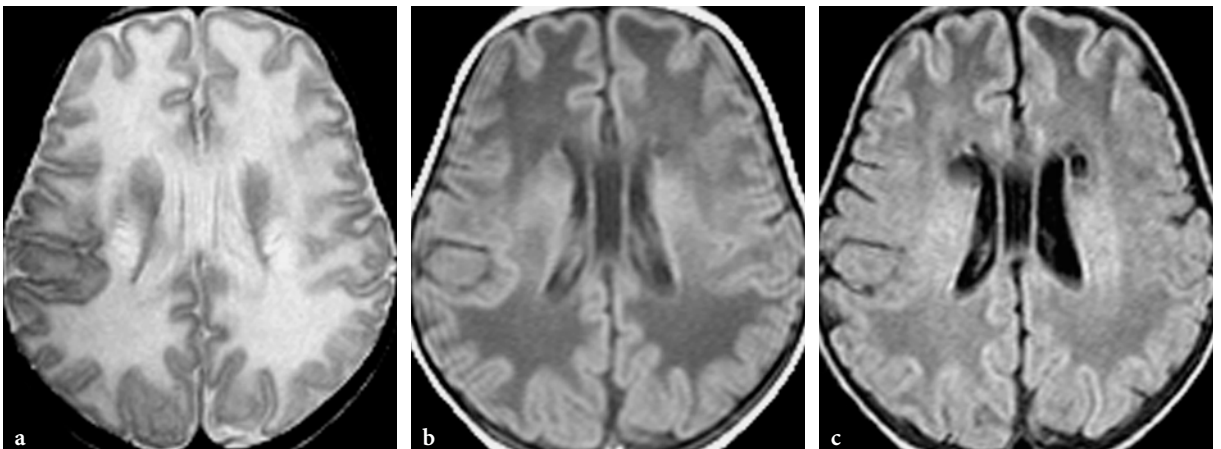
Germinolytic cysts in an 8-day-old female patient with maple syrup urine disease (same patient as in Fig. 13.51). a On the axial T2-weighted fast spin-echo image, periventricular cysts are not conspicuous. Increased signal within the pyramidal tracts is suggested, consistent with myelin edema. b On the T1-weighted spin-echo image, the cysts are faintly visualized. c FLAIR image enables easy identification, due to sharp contrast between fluid-filled cavities and adjacent brain parenchyma. The extensive vasogenic edema within the nonmyelinated white matter is well appreciated on all image types
